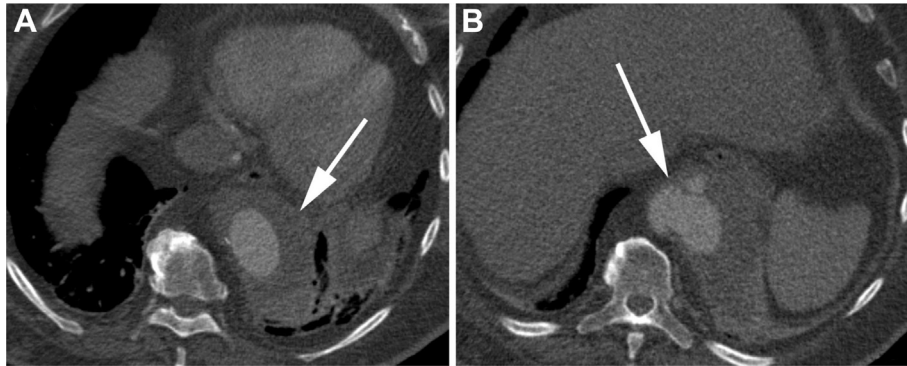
Preoperative axial computed tomography angiography (CTA) images. A, Axial CTA image showing the phlegmon (*arrow*) and lung involvement around the distal thoracoabdominal graft. B, Axial CTA image showing the distal anastomotic pseudoaneurysm (PSA).
